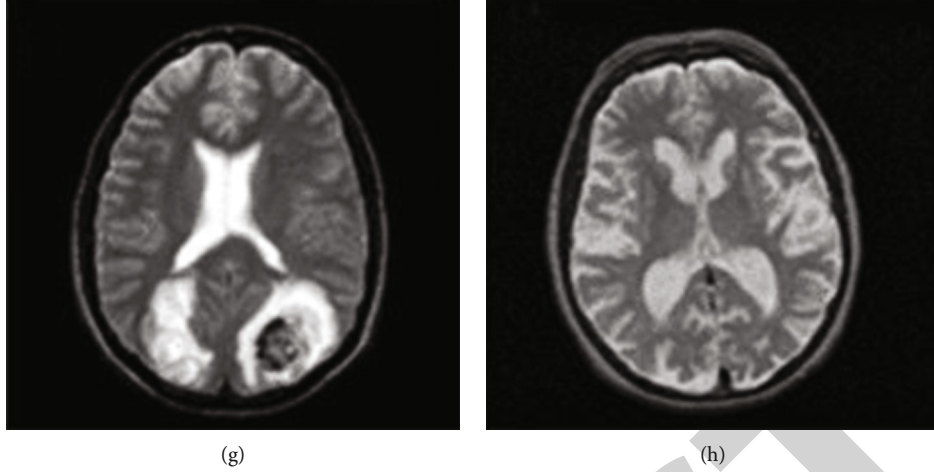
(a) Normal brain MRI, (b) glioma, (c) meningioma, (d) Alzheimer, (e) Alzheimer plus, (f) visual agnosia and pick's disease, (g) sarcoma, and (h) Huntington's disease.
